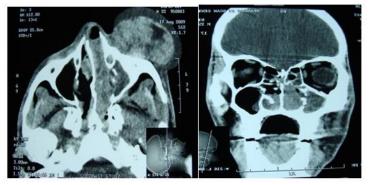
CT scan of PNS (axial & coronal sections) showing heterogeneous opacity in the both nasal cavities and left maxillary sinus along with dilatation of the left nasolacrimal duct
